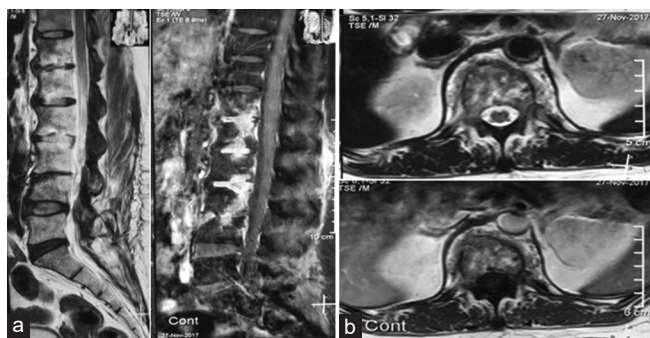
Loss of lumbar lordosis with narrowing of disc space of lumbar II–III; (a) sagittal plane and (b) axial plane of T2-weighted MRI showed marrow enhancement in thoracic XII–lumbar IV vertebral body and destruction of lumbar III–IV with paravertebral abscess formation
